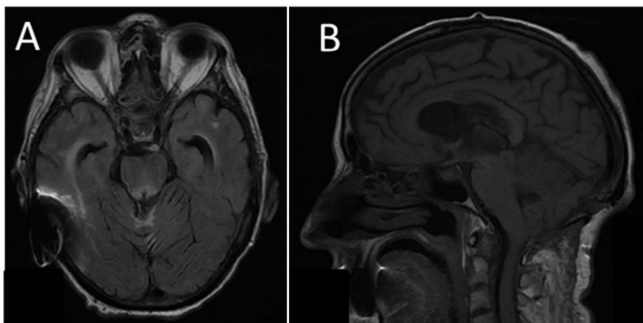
Post-operative MRI (A and B) shows gross total removal of the liponeurocytoma.
